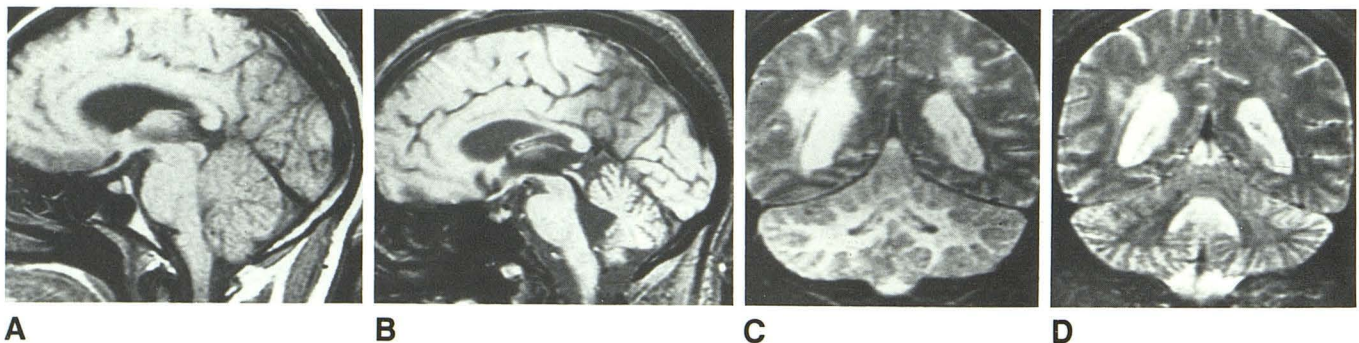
A and B, T1-weighted (600/20) sagittal MR scans through the midline of the brain. A, Before treatment, enlargement of pons, effacement of the fourth ventricle, and slight tonsillar herniation are present. B, 11 days later, pons is normal in size, and fourth ventricle is slightly enlarged. Tonsillar herniation has resolved and there is now prominence to the cerebellar sulci.
